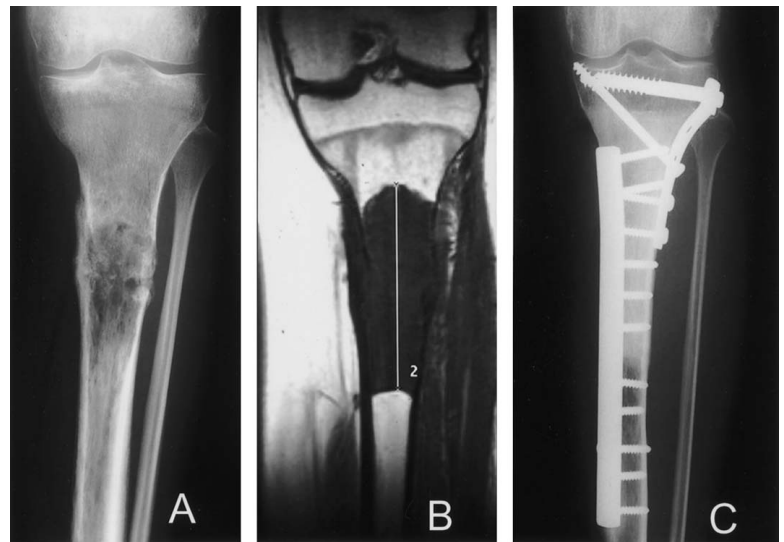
Imaging studies at the 6-year radiographic followup show a 25-year-old woman who was treated with an intercalary segmental allograft after the resection of a fibrosarcoma at the proximal tibia. (A) An AP radiograph shows the affected tibia with a metaphyseal lytic lesion with lateral cortical destruction and soft tissue extension. (B) An AP radiograph shows the allograft reconstruction that was obtained by the 6-year followup. A mature callus can be seen and osteotomy lines are not visible.
